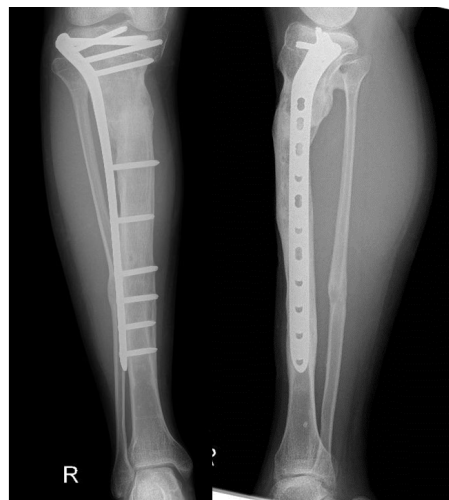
Case 2. X-ray at 2 years and 2 months after the operation. Bone union was completely achieved and good alignment
